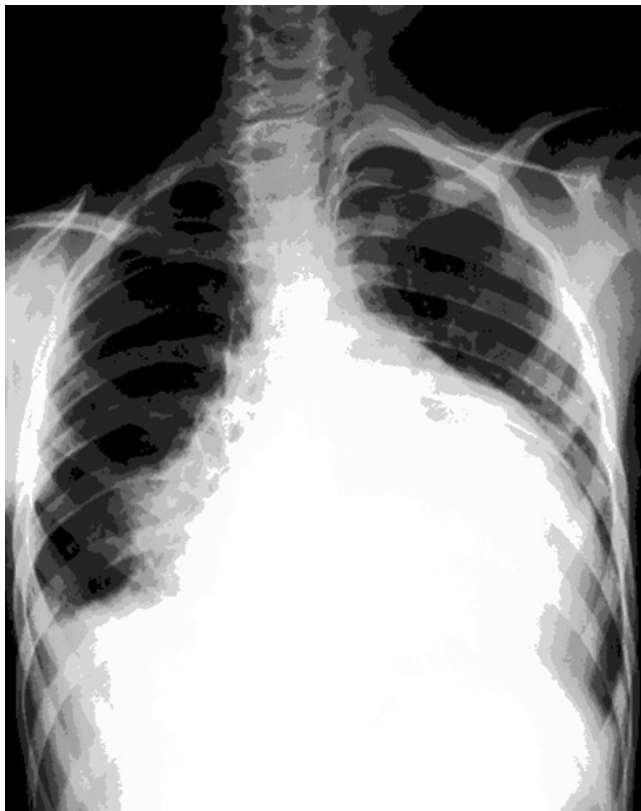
PA chest radiograph, showed that on the right lower lobe, localized pneumonic infiltration and enlargement on the pericardial shadow.
